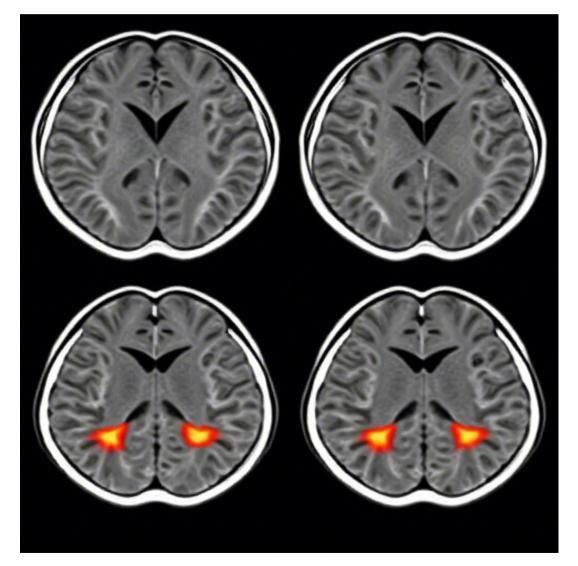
Al-Assisted Stroke Detection in Brain MRI Scans Al: Artificial Intelligence, MRI: Magnetic Resonance Imaging
